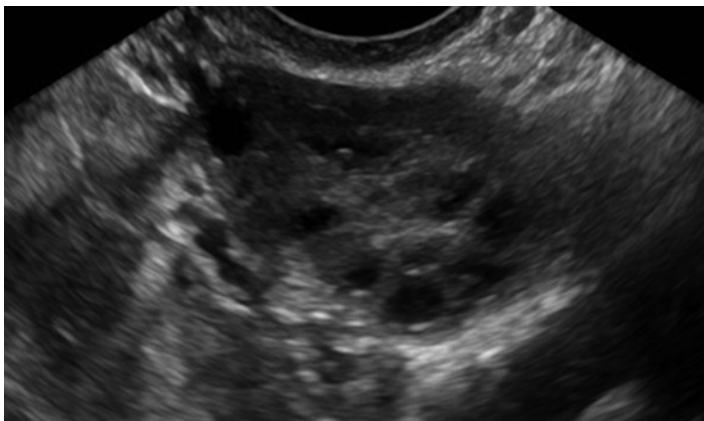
Polycystic ovarian syndrome. Transvaginal ultrasound of a 21-year-old patient with PCOS reveals several small, peripherally located follicles with a “string of pearls” appearance
